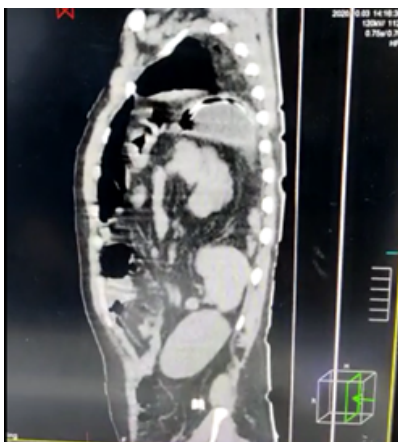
(CT thorax sagittal view showing herniated abdominal viscera)
